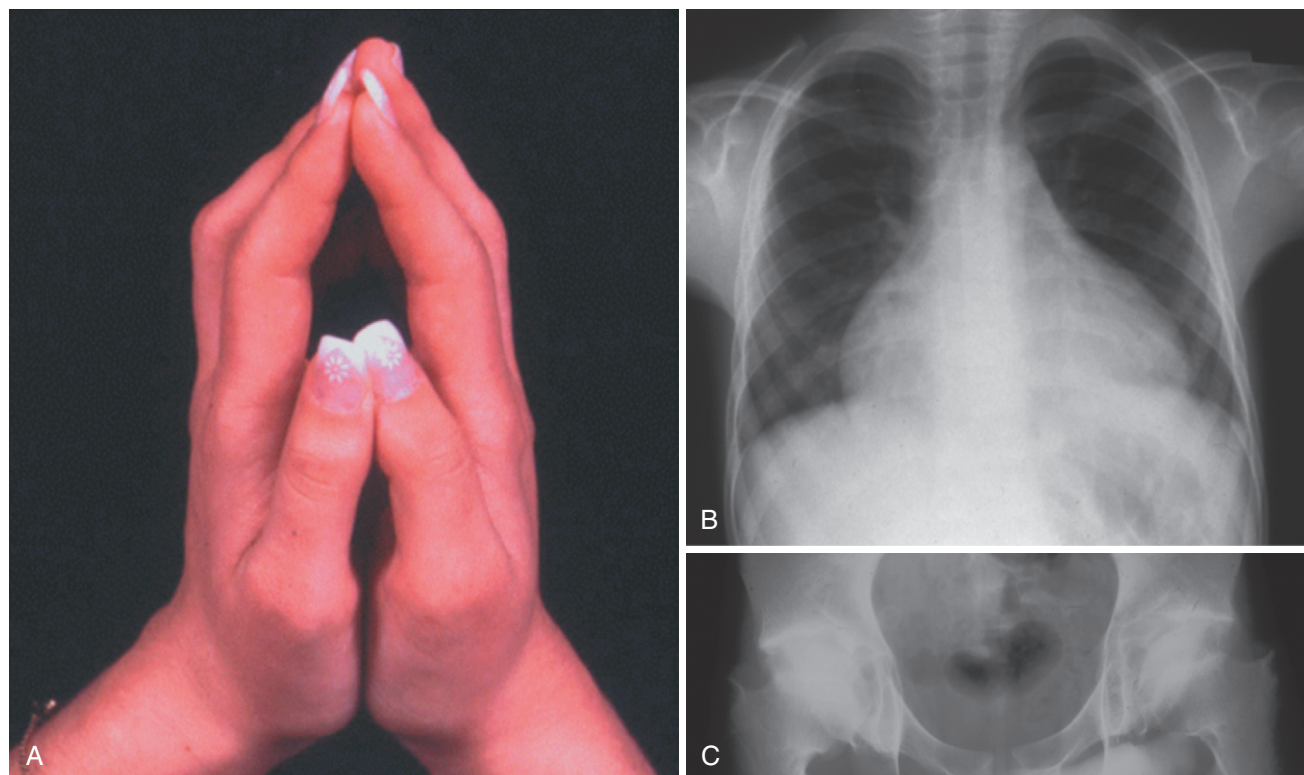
Clinical features of camptodactyly–arthropathy–coxa vara–pericarditis (CACP) syndrome. A, The characteristic deformity of the hands is shown. B, Chest x-ray shows an enlarged cardiac outline caused by pericarditis. C, X-ray of the pelvis highlights coxa vara in a boy with CACP. (B and C, Courtesy Ronald Laxer, MD, Hospital for Sick Children, Toronto, Ontario, Canada.)
